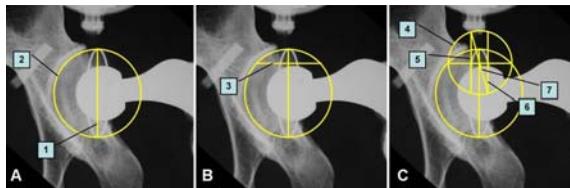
Measuring of radiographic anteversion
